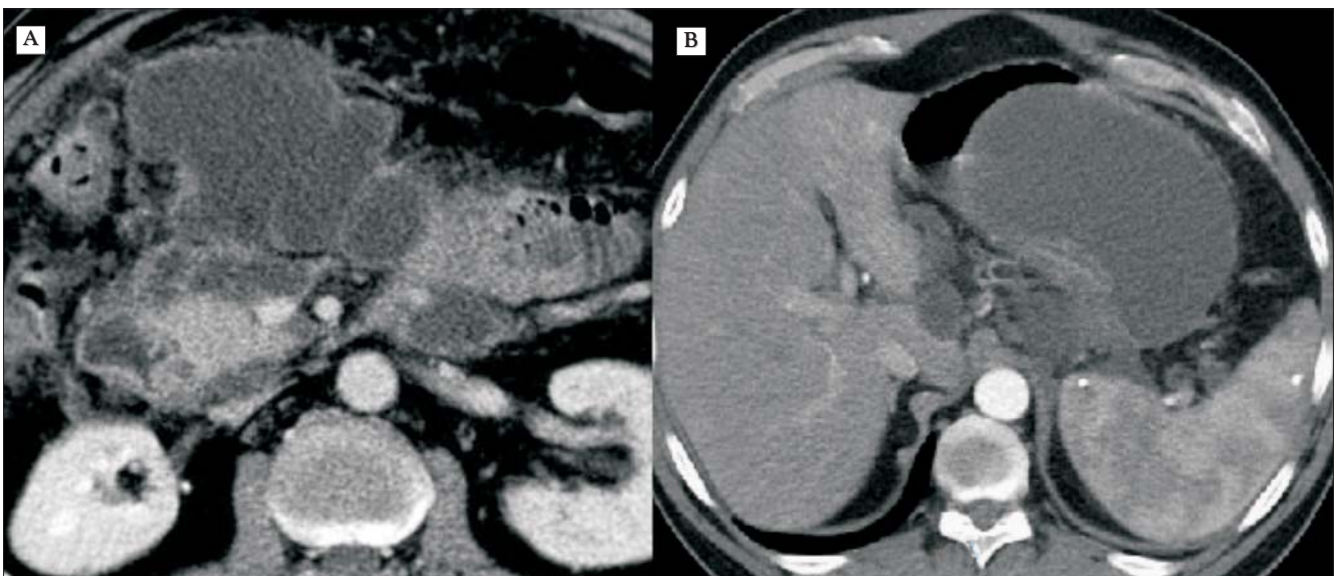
Abdominal CT scan showing (A) acute necrotizing pancreatitis with intra pancreatic necrosis and peripancreatic fluid collections; (B) large intergastro-pancreatic collection
